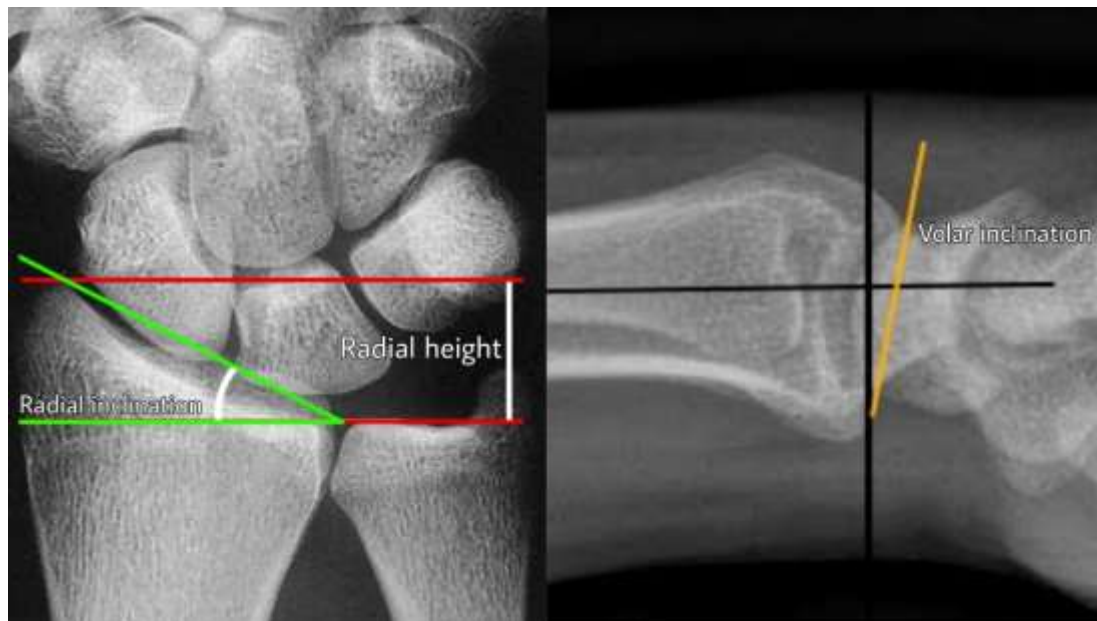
Distal radius radiographic parameters
